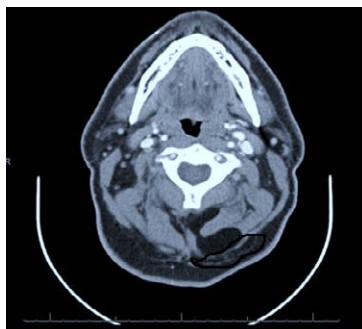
CT neck with contrast shows bilobular fat-containing lesion within the left paravertebral space measuring approximately 3.7 × 3.3 cm (arrow). The lesion is located at the level of C1-C2 in the suboccipital region.
